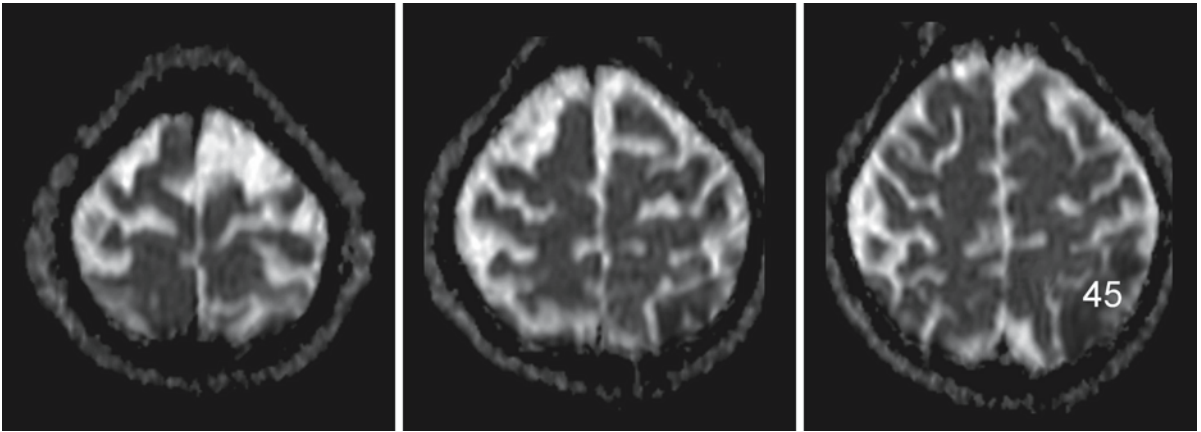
(continued). A 62-year-old man without cognitive complaints, presenting with left-sided hemianopia. The FLAIR images (*upper two rows*) show hyperintensities consistent with normal aging, except for the left parietal lesion, involving cortex and subcortical white matter. The gradient echo images (*third row*) show a few low-intensity spots in the left parietal
